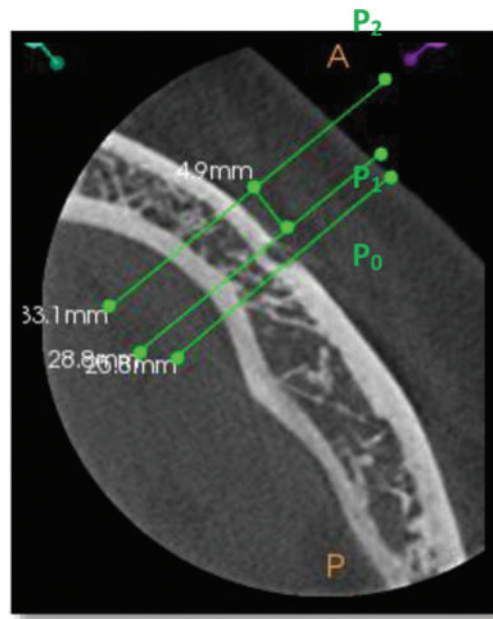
CBCT images with anterior loop length in oblique view. CBCT, cone-beam computed tomography
